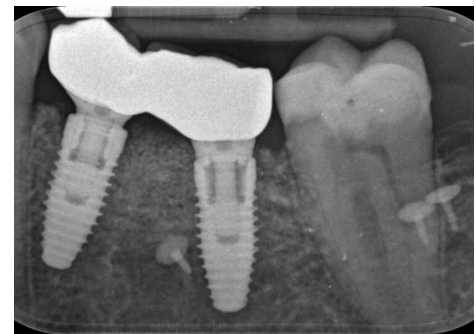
Peri-apical x-ray at loading.
